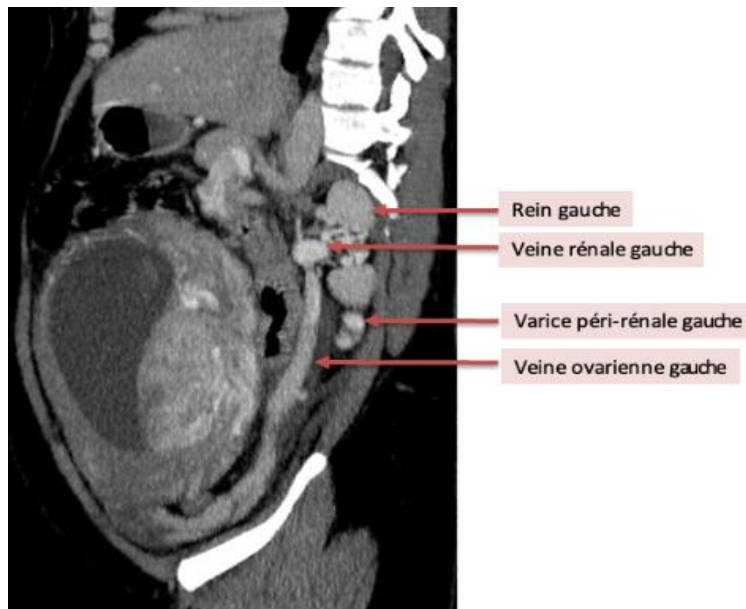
Sagittal section of our patient's abdominal-pelvic CT scan after injection of PDC, with MIP (maximal intensity projection) reconstructions, showing a dilated left ovarian vein, flowing into the left renal vein, with peri-renal varices.
